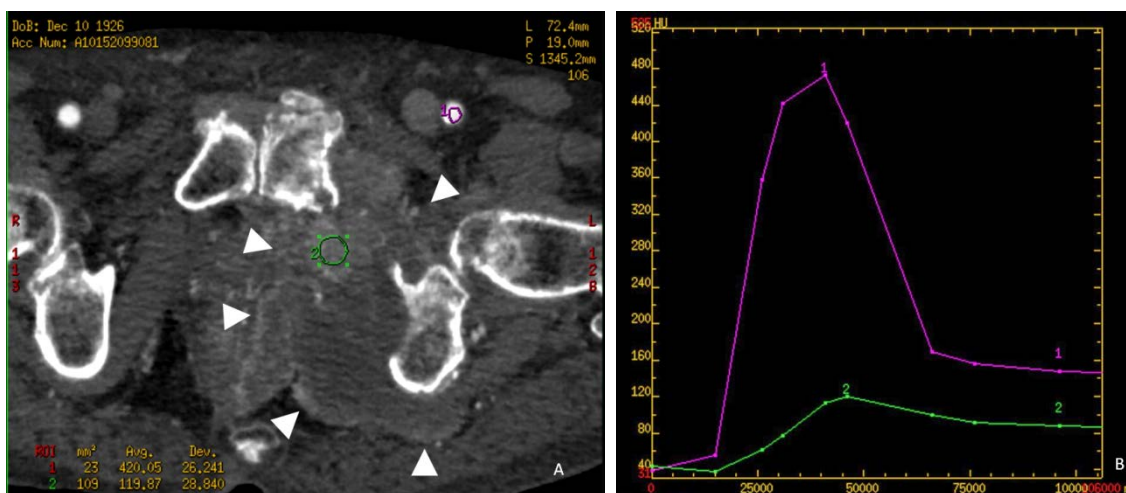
84 year-old male with a biopsy proven spindle cell sarcoma of the left acetabulum and left ischio-pubic branch. A) Axial CT images demonstrating the ROI placement in a large lytic bone lesion with soft tissue invasion at the level left ischio-pubic branch (green circle) and in the left femoral artery (purple circle). The white arrowheads delineates the mass contours. B) CT perfusion time-to-density curve (Hounsfield units x milliseconds) of the same patient demonstrating an early and steep enhancement of lesion (green curve) with respect to the artery (purple curve), followed by a washout (curve type IV).
